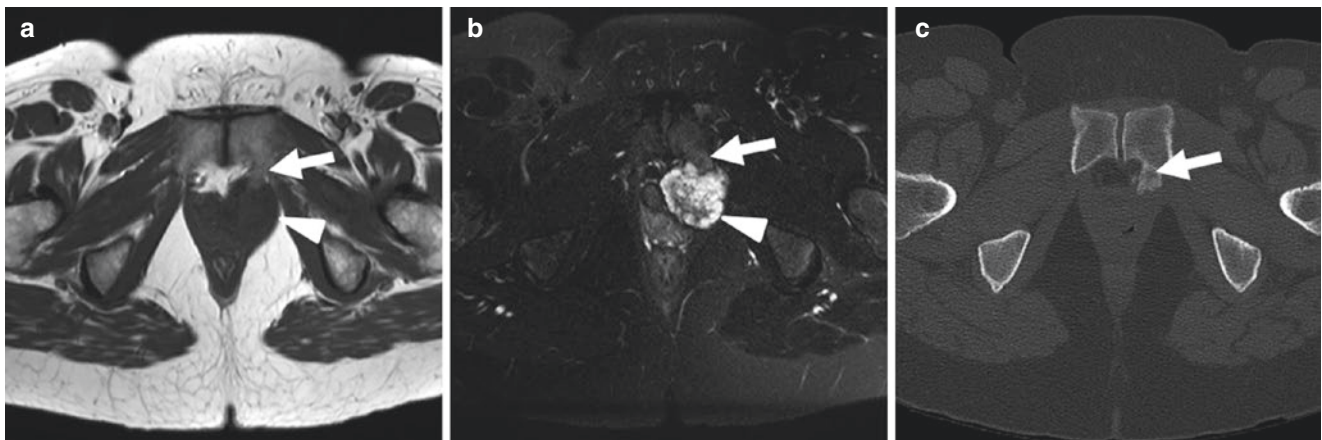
Axial T1- (a) and T2-weighted fat-saturated (b) MR images demonstrate a lobulated T2 hyperintense mass compatible with a cartilage tumor (a and b—arrowheads). An osseous stalk from the adjacent
